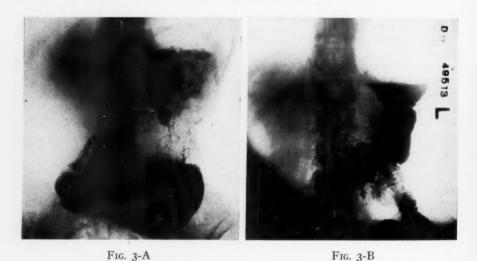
Case 8: Roentgenogram of high lesser curvature ulcer.
